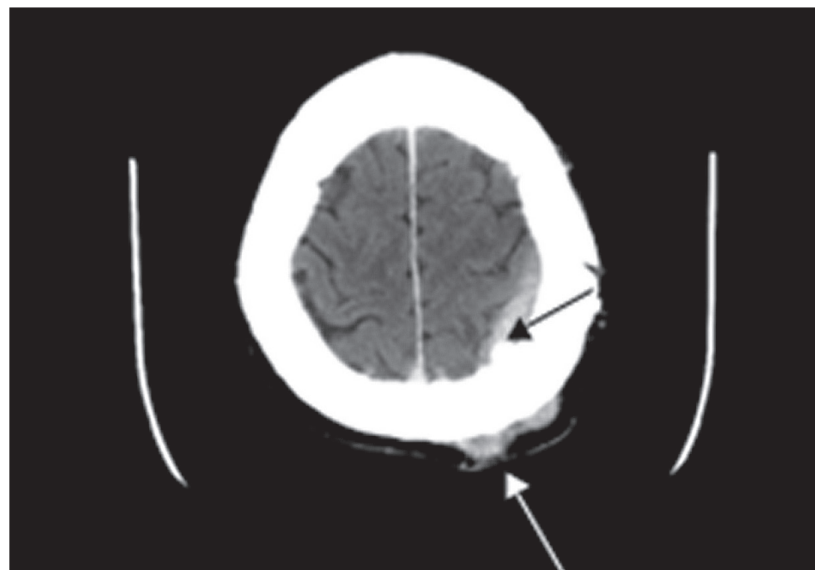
Coronal section of brain CT scan with contrast revealed multiple intracranial lesions and over the scalp at the region of left craniotomy.
